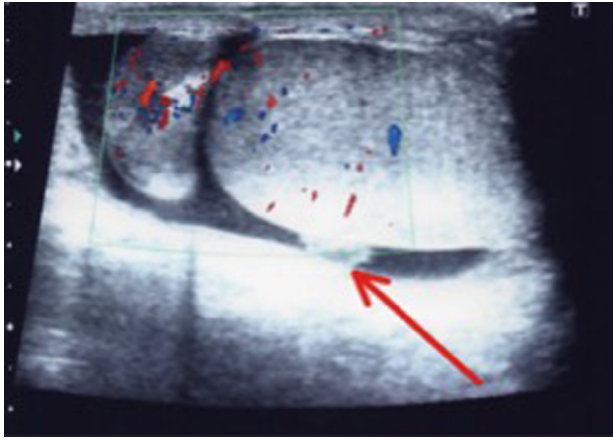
Ultrasonographical examination; red arrow indicates the tumor. (Color version available online.)
